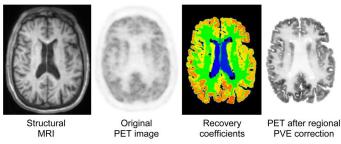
From Catana 2012⁵: The relatively low resolution of PET scans can lead to inaccurate estimations of volume due to Partial Volume Effects (PVE). However, thanks to the superior structural detail provided by MRI, and the elimination of registration problems because of simultaneous PET-MRI image acquisition, recovery coefficients can result in PET data with far greater detail and more accurate tissue activity concentrations.
